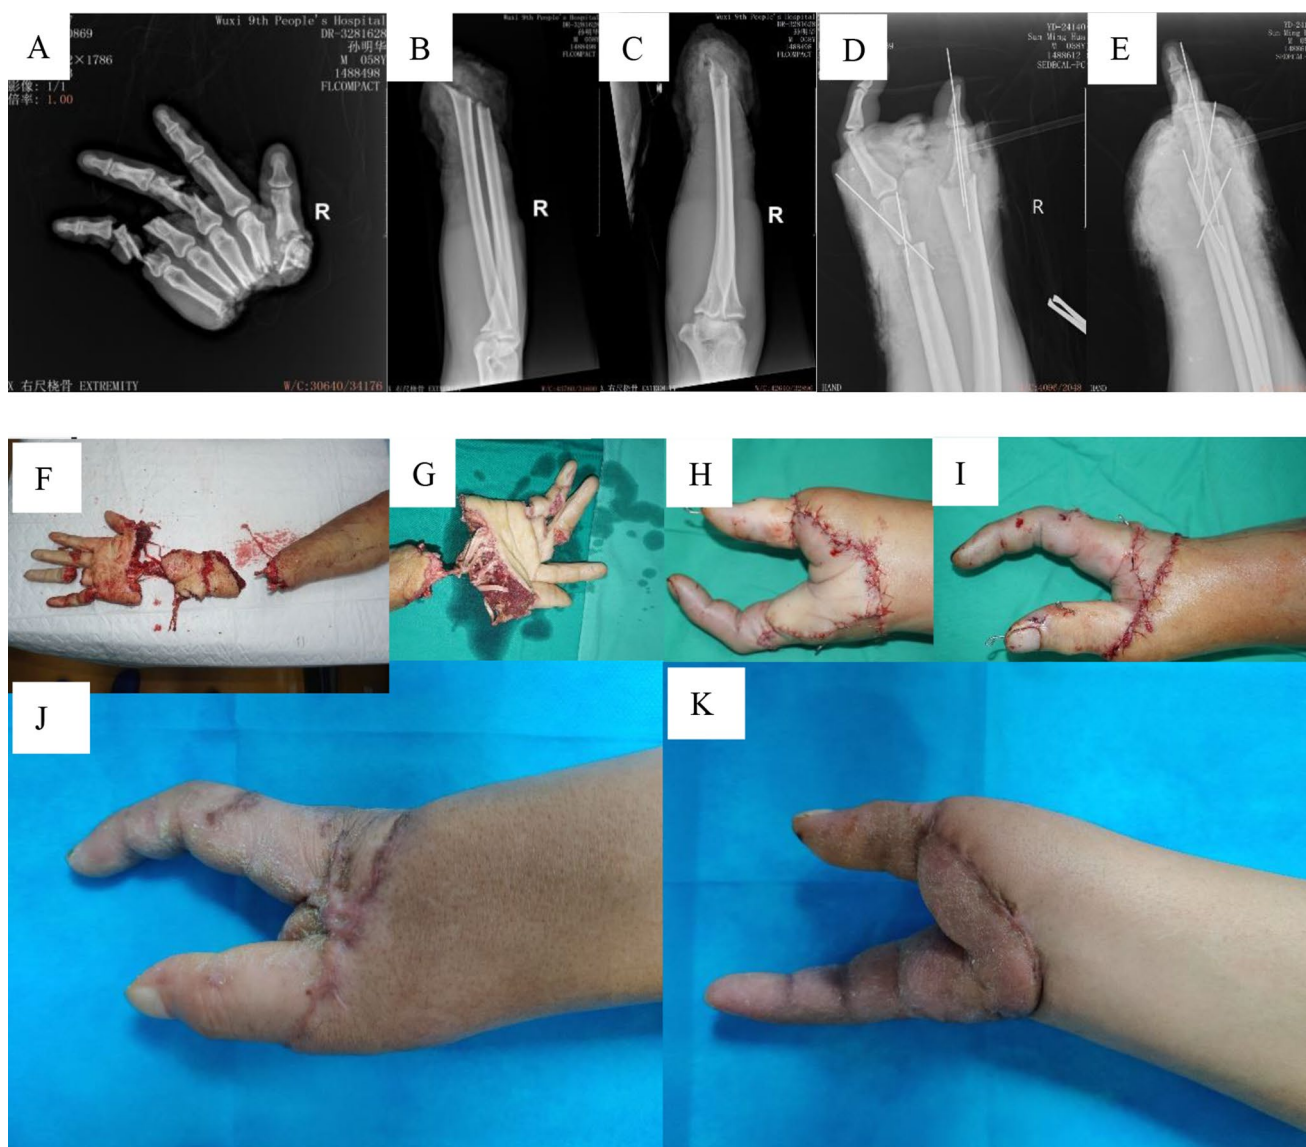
A 58-year-old man with complex wrist amputation combined with severed fingers due to a mechanical crush injury received emergency ulnar radial-metacarpal reconstruction. A-C. Pre-operative X-ray;
